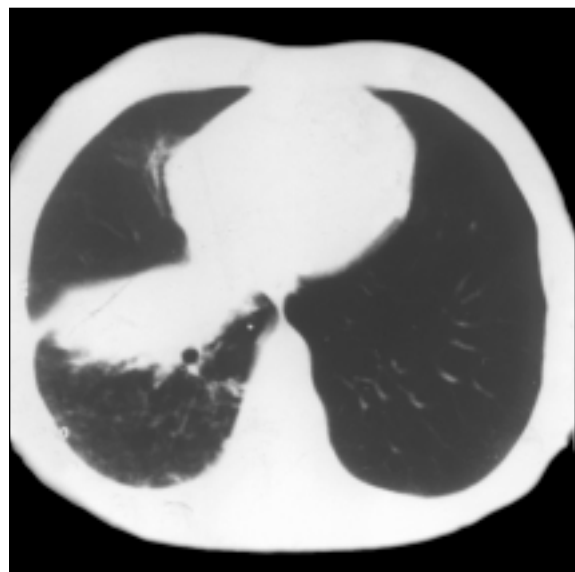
CT of thorax demonstrates infiltration and atelectasis on right lower lobe.
